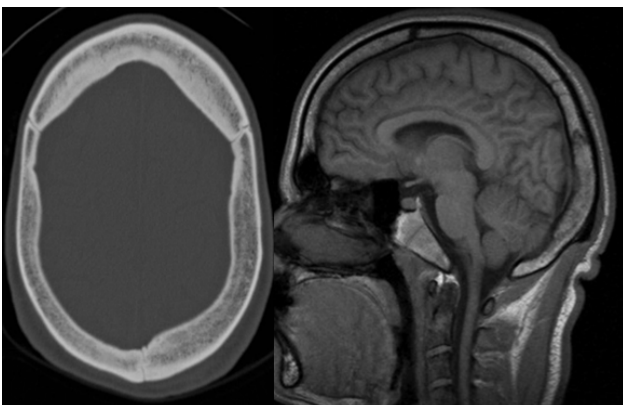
Skull CT, bone window (left). Cranial MRI, T1. Isolated diploic and internal table thickening without known metabolic abnormalities. Hypersignal T1 (fatty).
